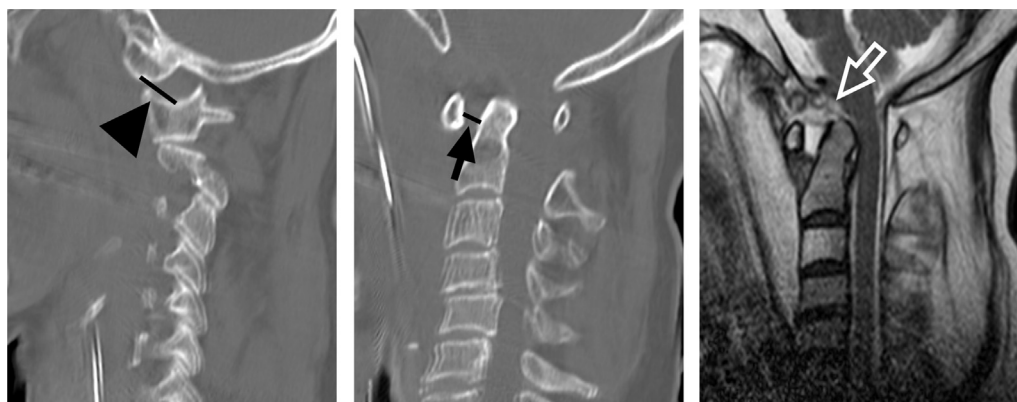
Initial left parasagittal computed tomography CT (Left), sagittal cervical spine CT (Middle), and T2-weighted magnetic resonance imaging (Right). (Left) Condylar gap (CG, closed arrowhead), the distance between the condyle and superior facet of the atlas, was 13 mm (normally <2 mm). (Middle) Atlantodental interval (ADI, filled arrow, normally <3 mm) was 6 mm. (Right) Dural sac was mildly pinched between the posterior arch of C1 and the odontoid process. Ligamentous ruptures were suggested by regions of high intensity (open arrow).
